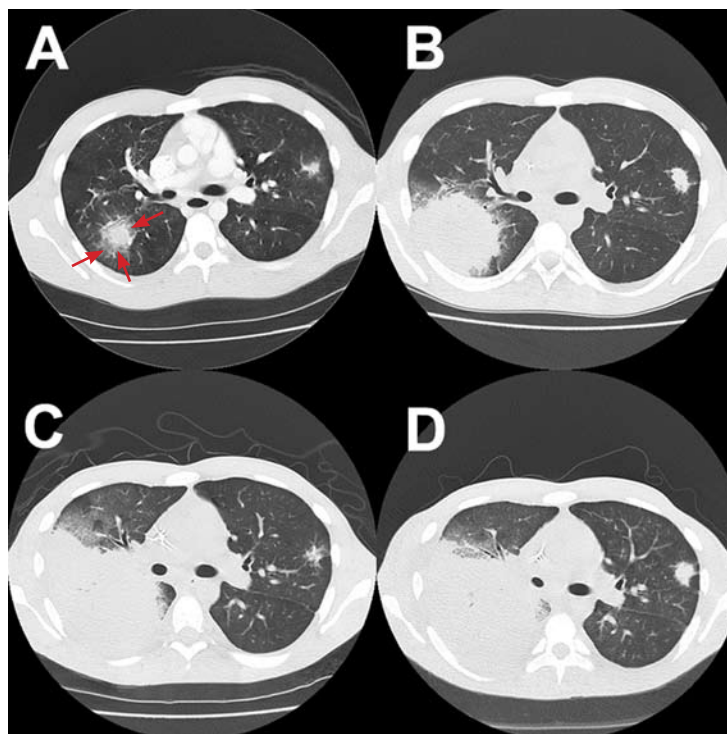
Sequential axial computed tomographic images of the chest in the course of 1.5 months. Note the progression of lung infiltrates in the right and left upper lobes, as well as the “halo sign” (arrows in image A). The patient had associated pleural effusion and progression of the infiltrate in the right side to the lower lobe, as seen in images C and D. He had a second bronchoscopy and began appropriate therapy after image C.
